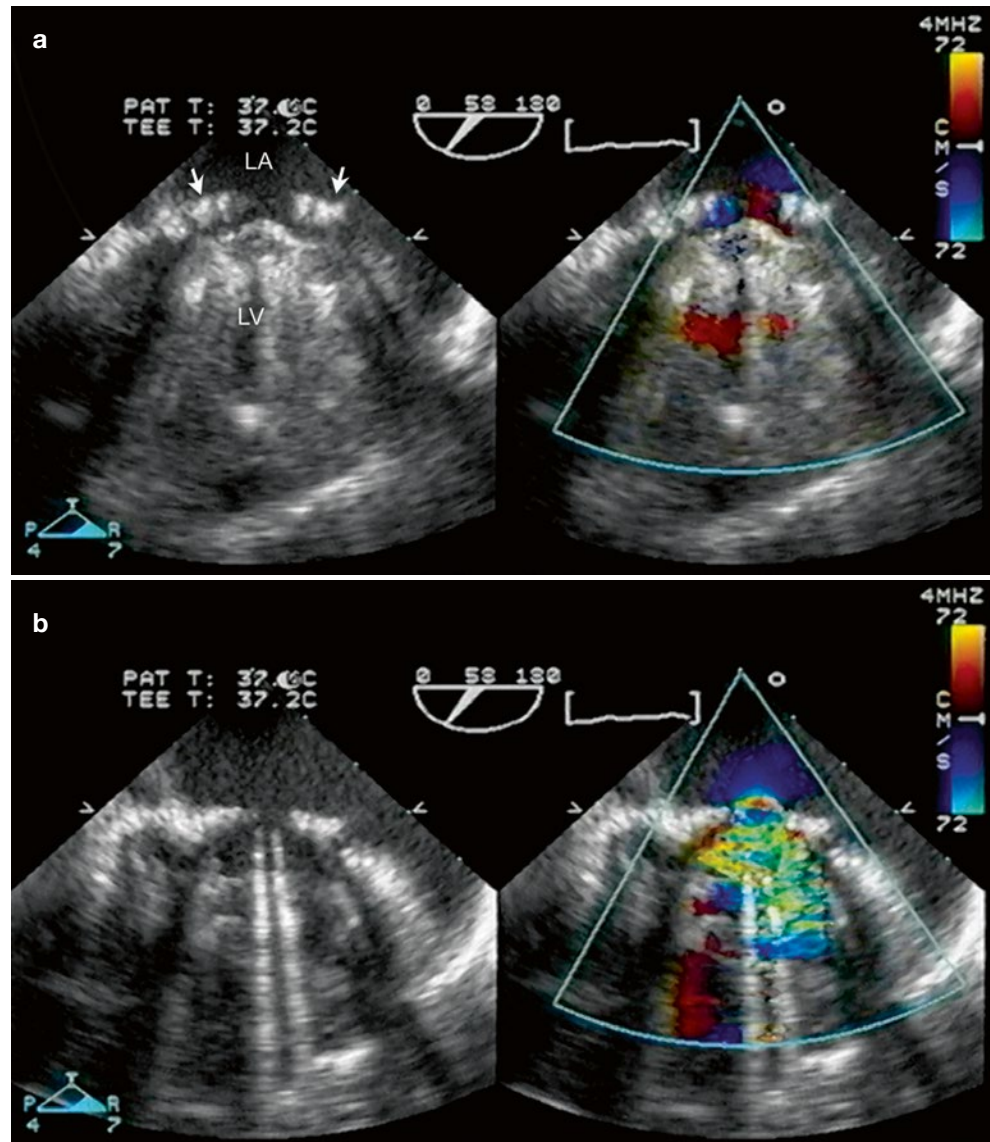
Prosthetic mitral valve (St Jude bileaflet disk). Mid esophageal view mitral commissural view, multiplane angle 69°. The multiplane angle is rotated until both leaflets are profiled and open symmetrically in diastole (a) and systole (b). (a) There is the usual color flow Doppler profile across the valve (*see* text for details). (b) In systole, the “normal” pivot point washing jets are seen. *LA* left atrium, *LV* left ventricle
